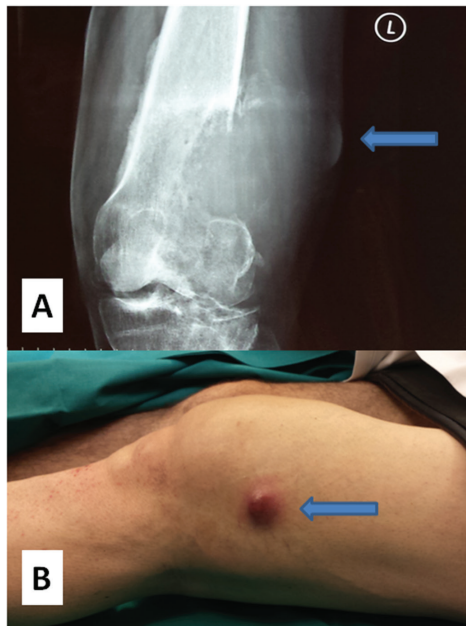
A: anteroposterior x-ray and B: Clinical image, denoting the subcutaneous nodule due to needle track seeding (blue arrow).
